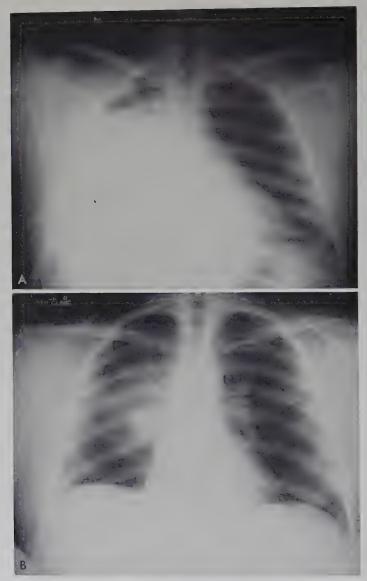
Roentgenograms of chest of patient with pulmonary hematoma after gunshot wound, A. Roentgenogram day of injury shows diffuse pulmonary parenchymal hemorrhage, B. Roentgenogram six weeks later shows resolution and consolidation of the hematoma. This hematoma might be considered a tumor were it not for history of injury.
